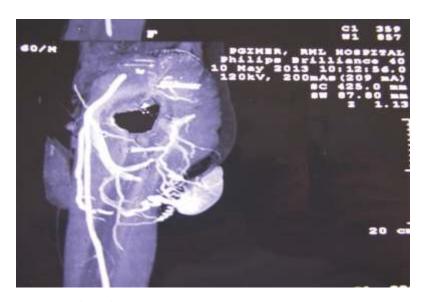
Contrast Enhanced CT of Right Thigh Revealed an Areterio-Venous Malformation with Soft Tissue Attenuation Vascular Mass
